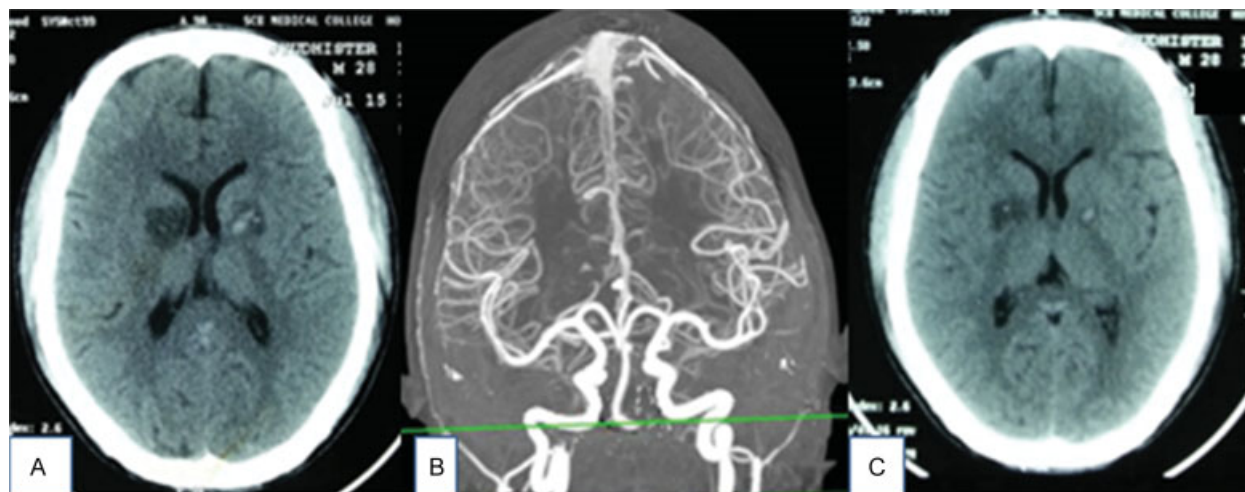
(A) Noncontrast computed tomography scan of the brain showing right basal ganglia infarct with left basal ganglia hematoma. (B) Computed tomography angiography showing normal vascular anatomy with no abnormality. (C) Follow-up noncontrast computed tomography scan showing resolving left basal ganglia contusion with right basal ganglia infarct.
